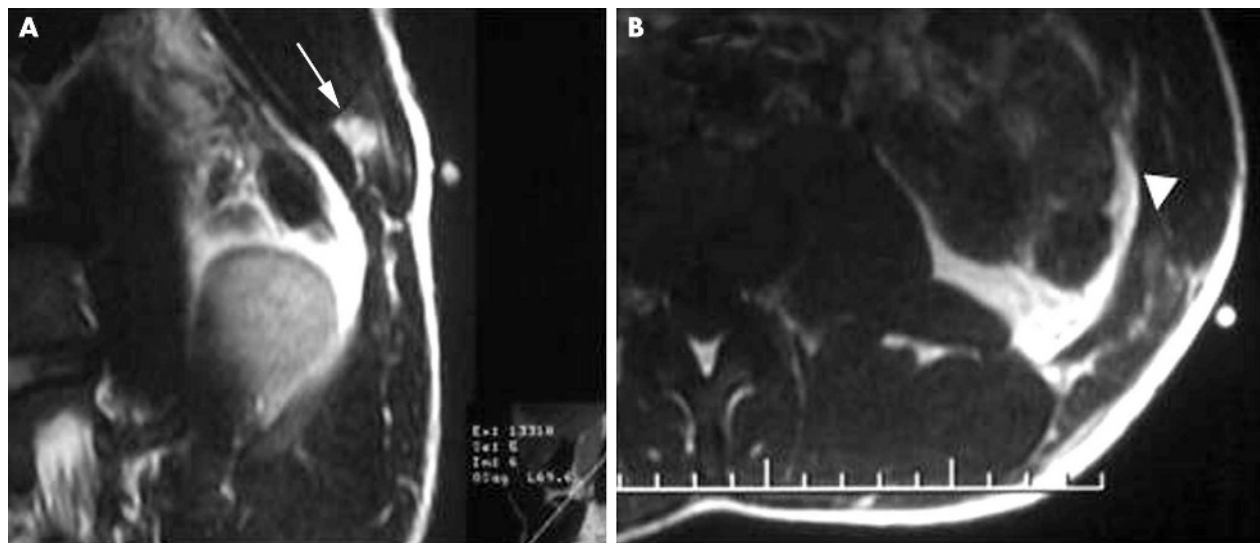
(A) T2 weighted axial oblique magnetic resonance image of left abdominal wall in a professional tennis player. There is focal abnormal signal intensity in the upper portion of the internal oblique muscle (arrow) compatible with strain. The hyper-intensity area in the surrounding soft tissue represents perifascial oedema. (B) T1 weighted axial image of the same patient showing high signal intensity at the tear site indicating the presence of blood, which characterises the acute phase of muscular strain (arrowhead). Surface marker has been placed over the region of clinical concern.
